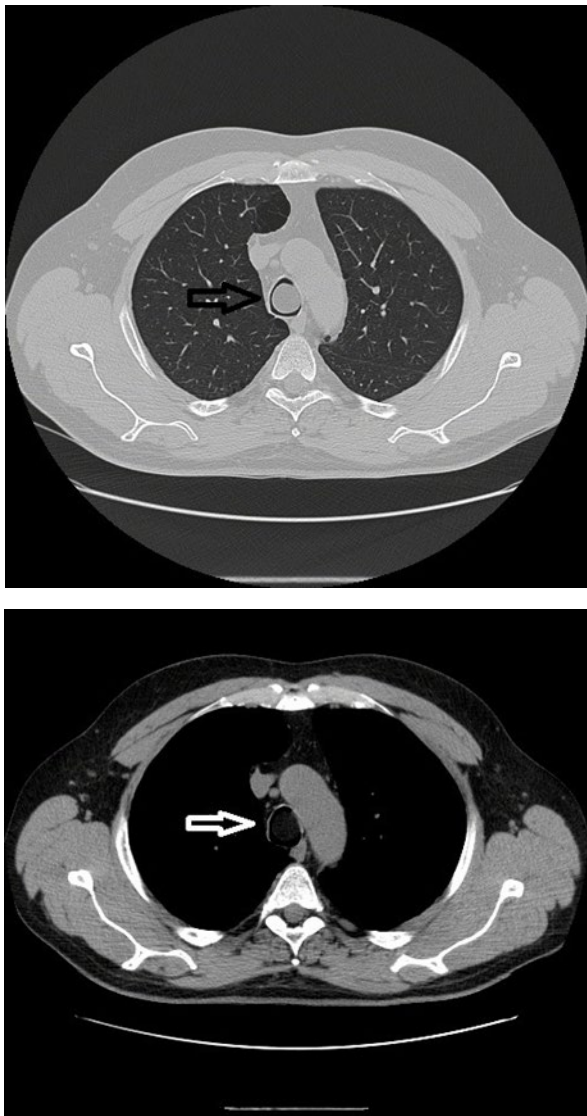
CT scan of the thorax at the level of aortic arch: on the left – lung window, on the right – mediastinal window, the arrows indicate a lesion in the tracheal lumen
